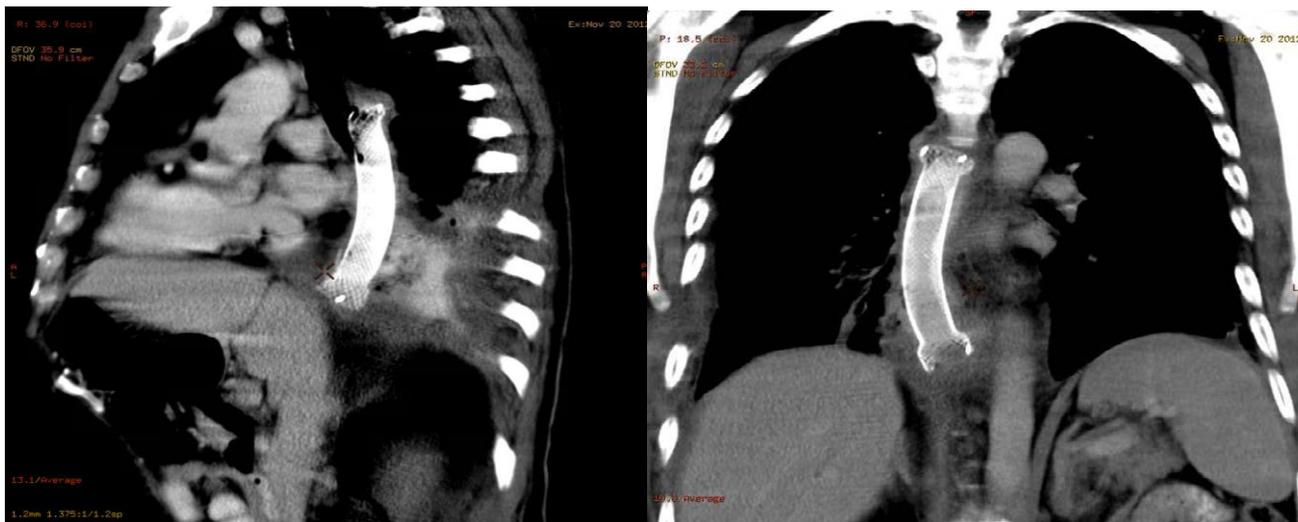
CT images 3 months after surgery; stent in position.
